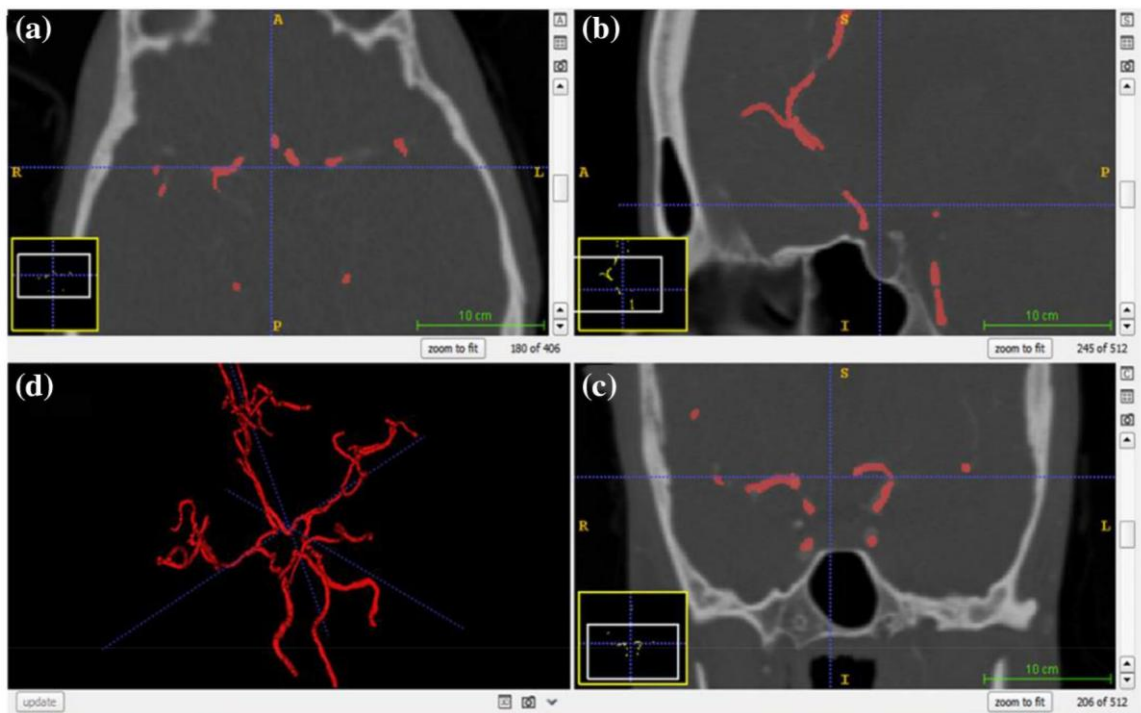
A segmented vasculature is shown of the original CTA image with the help of ITK-SNAP s/w
